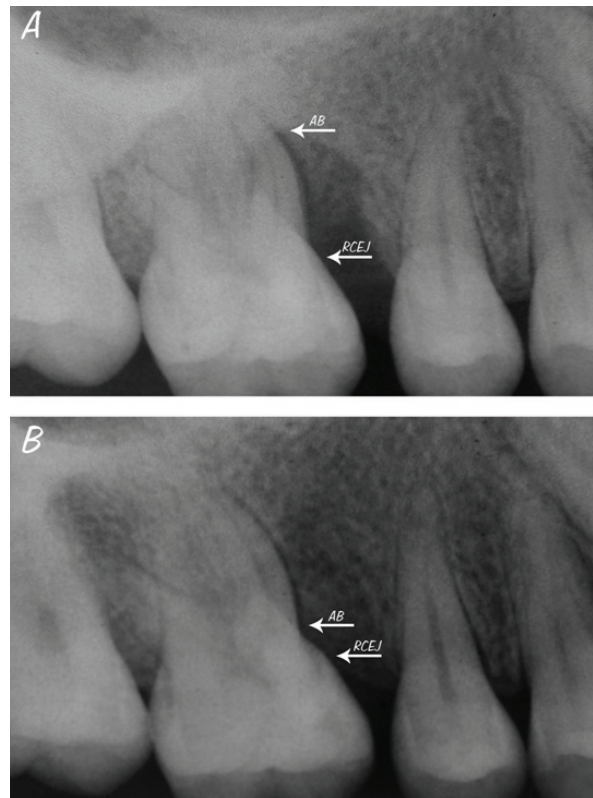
Radiographic appearances of an intraosseous defect treated with ACB grafting alone (CEJ, cementoenamel junction; AB, alveolar bone). A. Before treatment B. After treatment.
